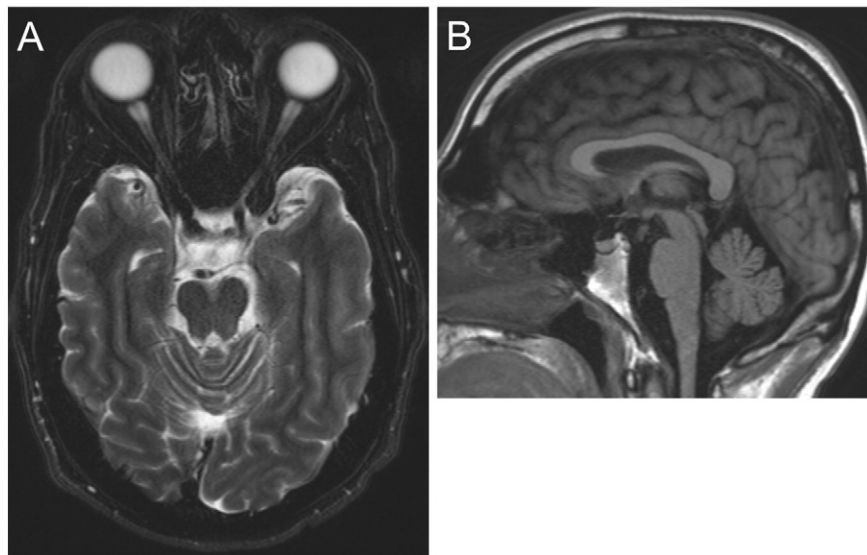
Brain MRI images. Atrophy of the optic nerves and optic chiasm (A, axial T2) and mild generalized cerebral and cerebellar atrophy (B, sagittal T1 FLAIR).
